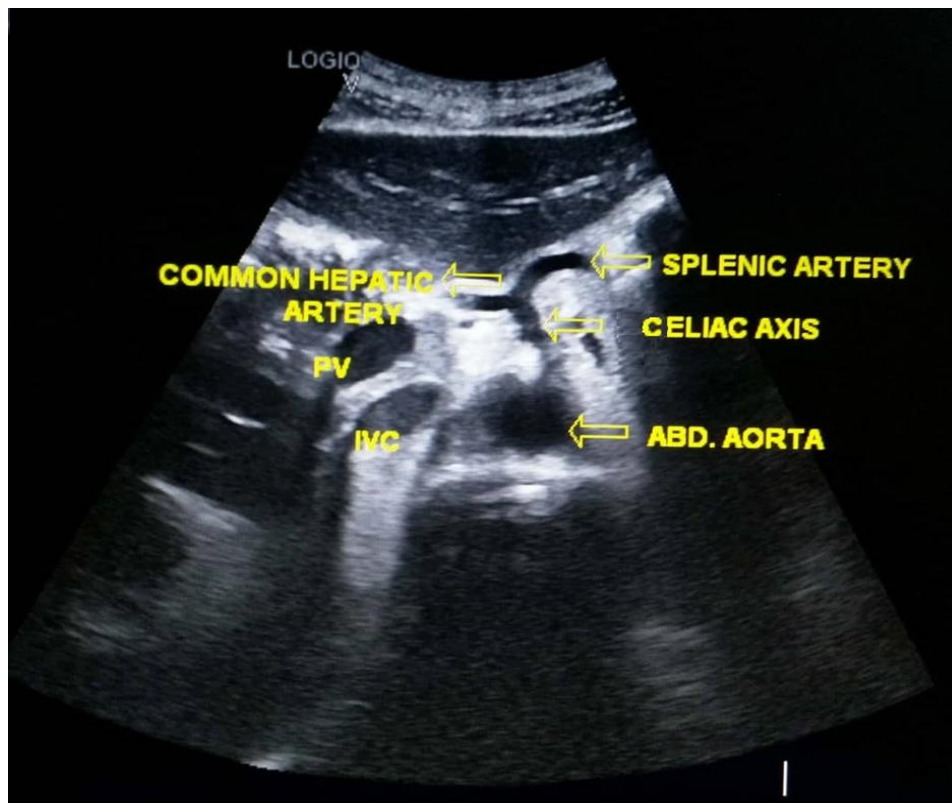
Transabdominal ultrasound image showing site of neurolytic agent injection at the base of the celiac axis. PV= Portal vein, IVC=Inferior vena cava
